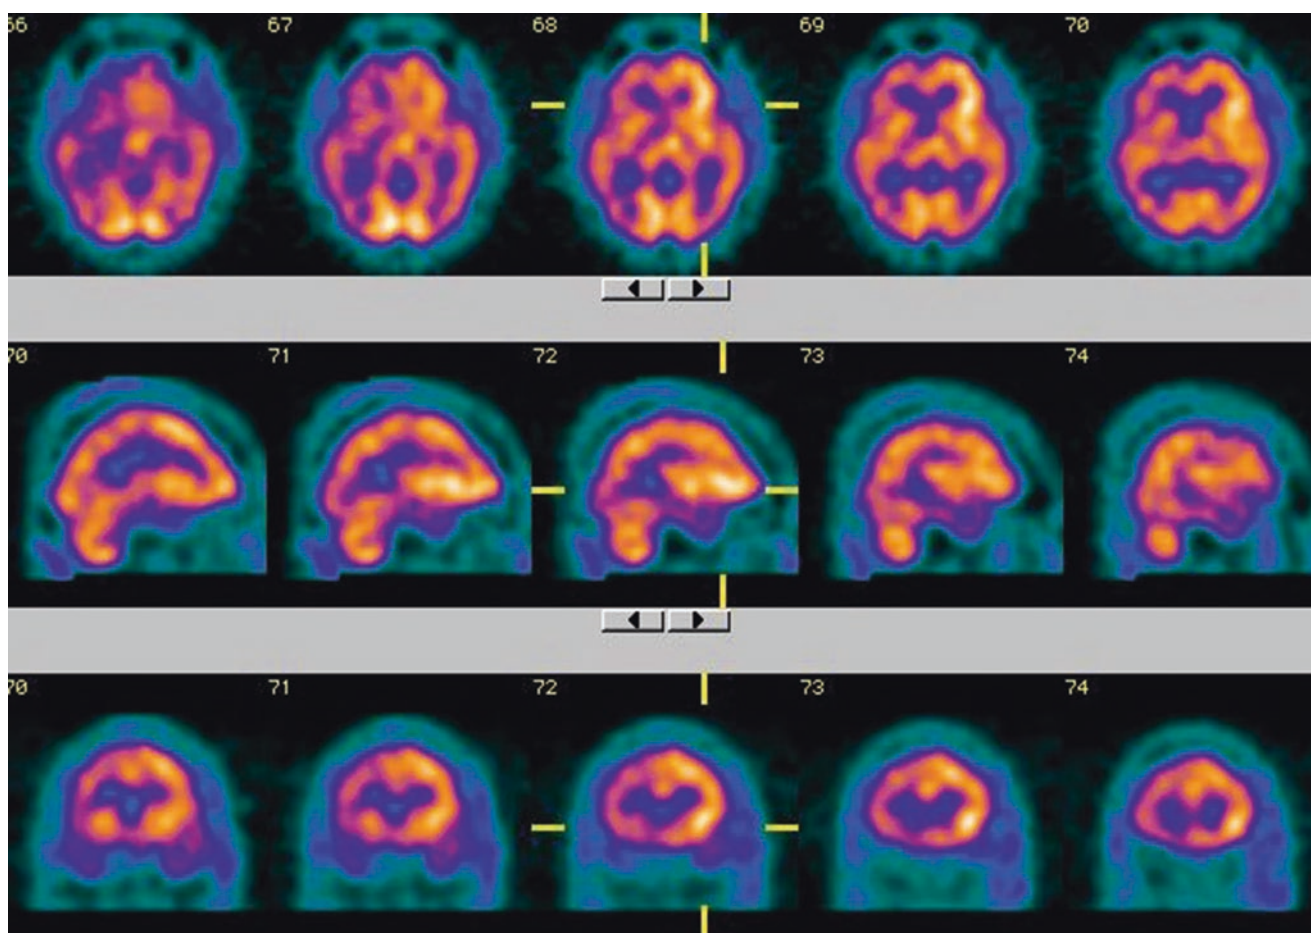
A SPECT study of a patient 12 months after a severe head trauma showing diffuse reduced regional cerebral flow (rCBF) in the right frontal, temporal, and parietal lobes, explaining the patient cognitive symptoms
